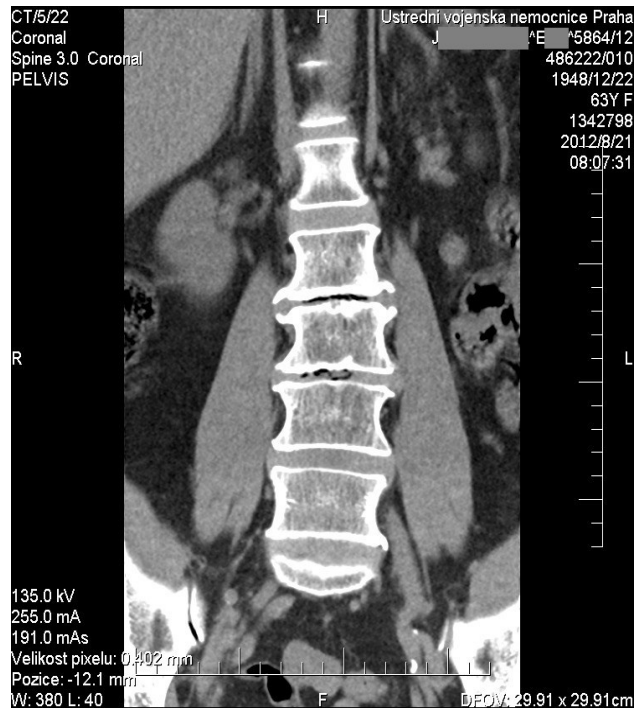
Computed tomography imaging of the patient's lumbar spine in coronal plane.
